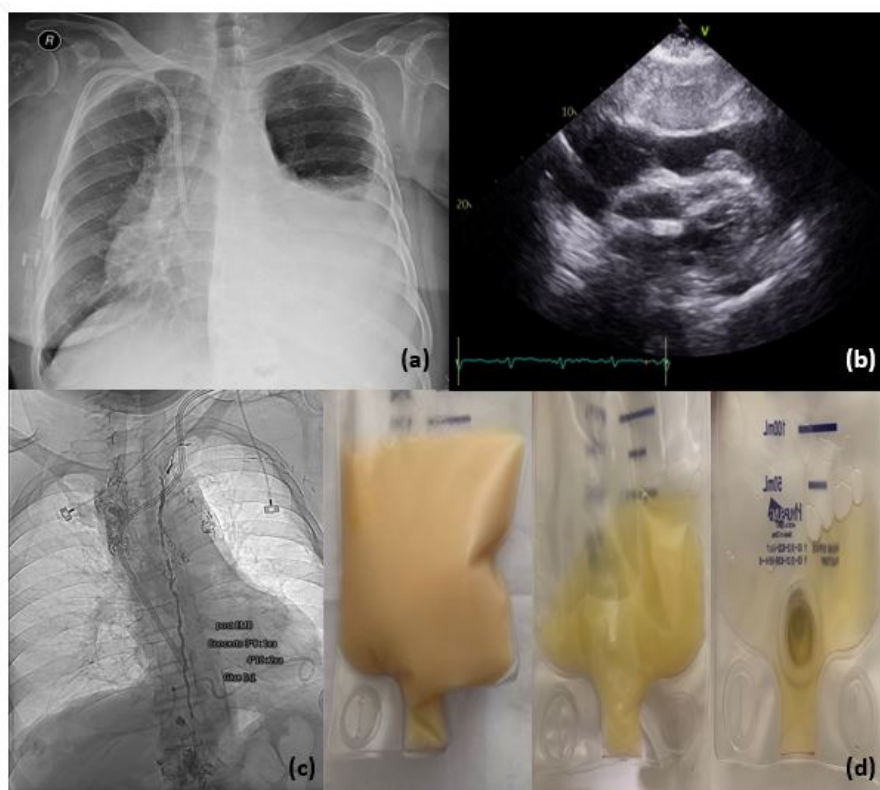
(a) An initial chest radiograph revealed massive pleural effusion (b) Echocardiogram demonstrated the cardiac tamponade (c) Lymphangiography and embolization (d) pericardial fluid drained showing milky white fluid
